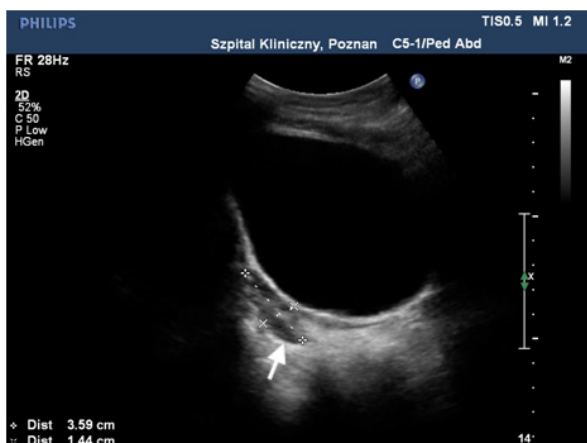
An ultrasound scan of the twisted, 3.6x1.4 cm left ovary (white arrow) in a premenarchal girl. Visible hypoechoic mass attached to the upper left side of the left ovary seven months after an oophorectomy
